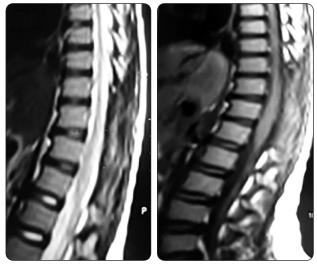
Postoperative sagittal T1-weighted MRI after 6 months with improvement in cord swelling.
